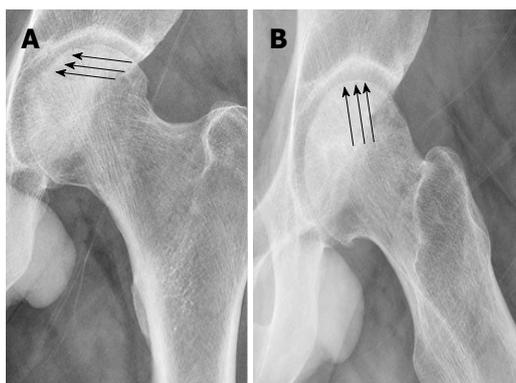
Left hip anteriorposterior and cross leg lateral X-rays showing (arrows) the crescent sing.
